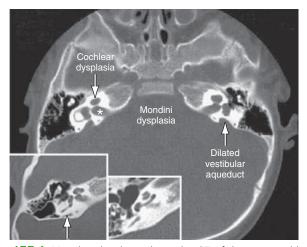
Mondini dysplasia shown by CT of the temporal bone in a child with Pendred syndrome. Both dilation of the vestibular aqueduct and cochlear dysplasia are present in this section. In the larger of the two inset images of a normal temporal bone, the vestibular aqueduct is visible but much smaller (arrow). The cochlea appears normal, and in the smaller inset image of a more inferior axial section, the expected number of cochlear turns can be clearly counted. Internal auditory canal (asterisk). (From Smith RJH, Bale JF Jr., White KR. Sensorineural hearing loss in children. Lancet. 2005;365:879–890.)
